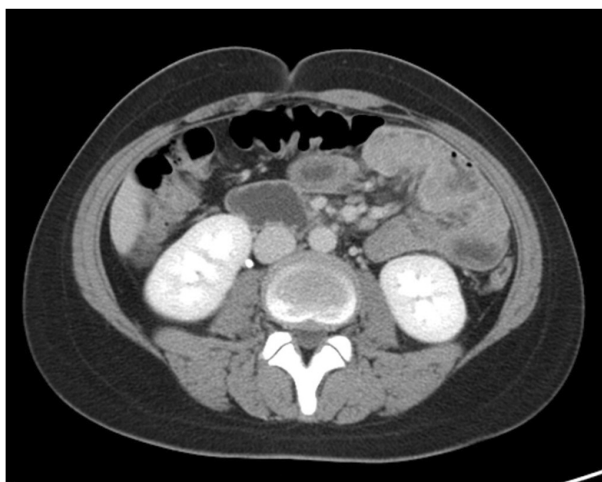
Abdominal CT finding. It revealed segmental eccentric wall thickening of the jejunum which indicated a pathology of lymphoma or adenocarcinoma.
